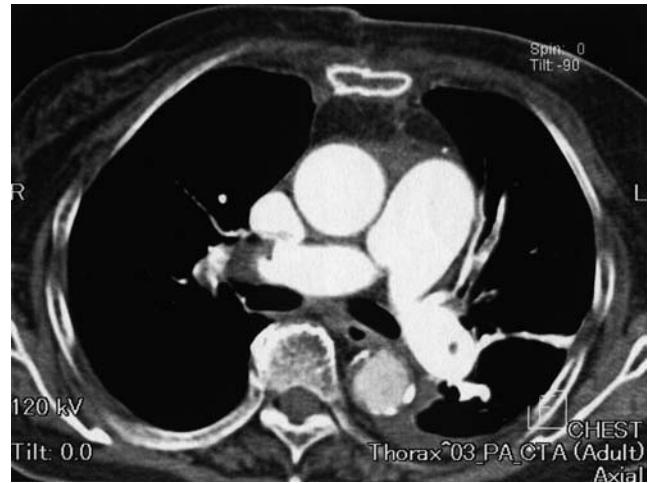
Contrast multislice computed tomography revealed a massive embolus in the pulmonary artery
